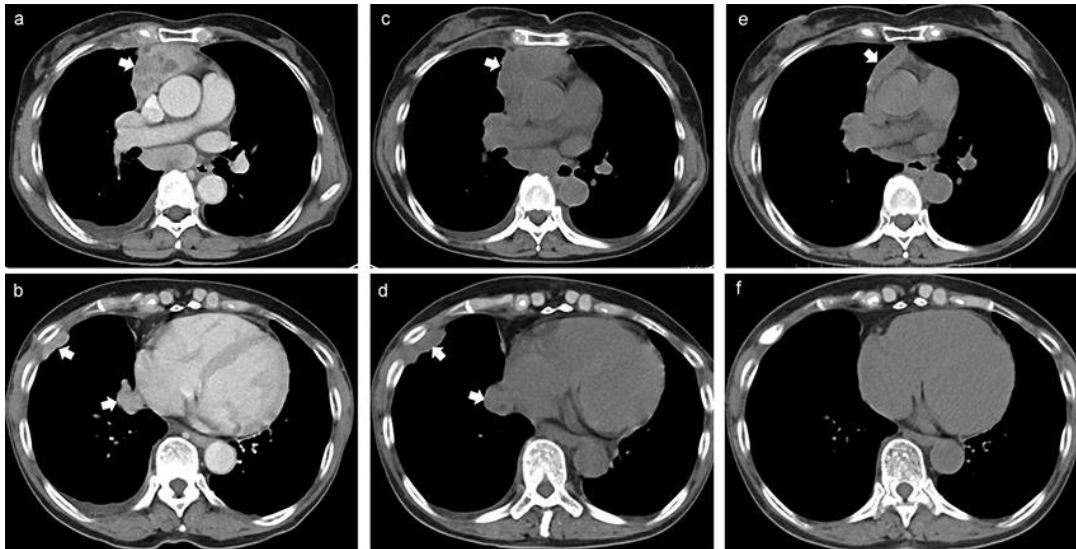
Chest computed tomography (CT) images. a, b Chest contrast-enhanced CT images on admission. The white arrows indicate an anterior mediastinal tumor (a) and disseminations in the right pleura (b). c, d CT images after 3 cycles of first-line chemotherapy. The metastatic lesions of the right pleura had grown larger (d). e, f After 6 cycles of pembrolizumab treatment, the primary lesion and metastatic lesions were markedly smaller.
